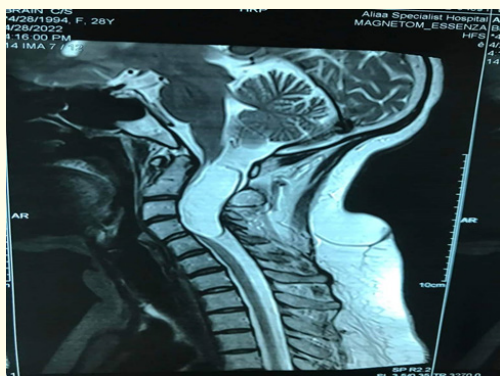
MRI cervical spine T2 showed hyper intense intradural extramedullary lesion.
